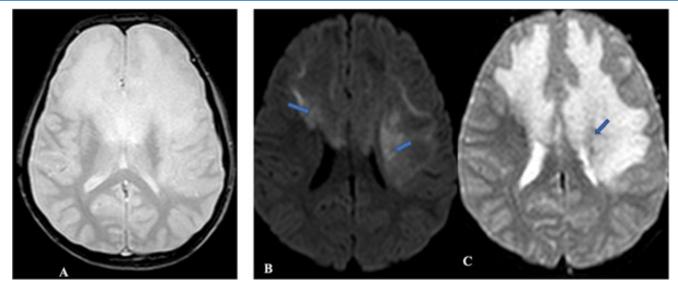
MRI images A-Axial GRE image shows no areas of blooming artifact in the lesion. (B-DWI and C-ADC)-The lesion shows diffusion restriction in its peripheral aspect (arrow) showing high signal intensity on DWI and low signal intensity on ADC mapping.
